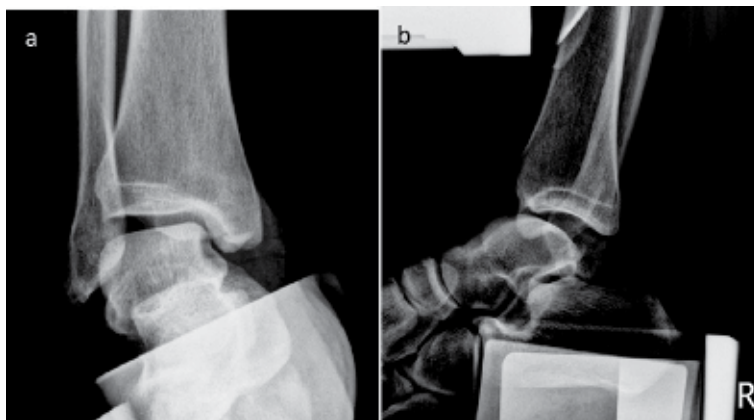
Dynamic radiographs. A dynamic test using the Telos stress device showing marked varus tilt and anterior subluxation of the talus.
